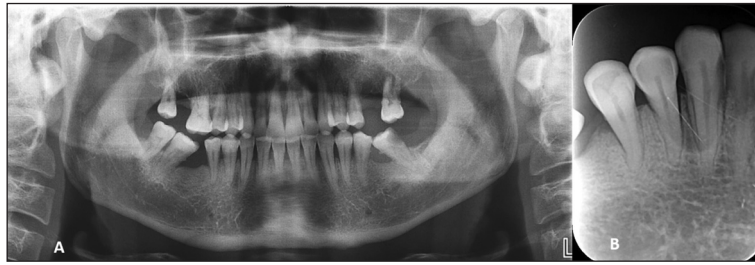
(A-B): Conventional radiographic images of the case. A: No finding observed on the panoramic image. B: A shadowy radiolucency superimposed on the related teeth roots on the periapical radiography.
